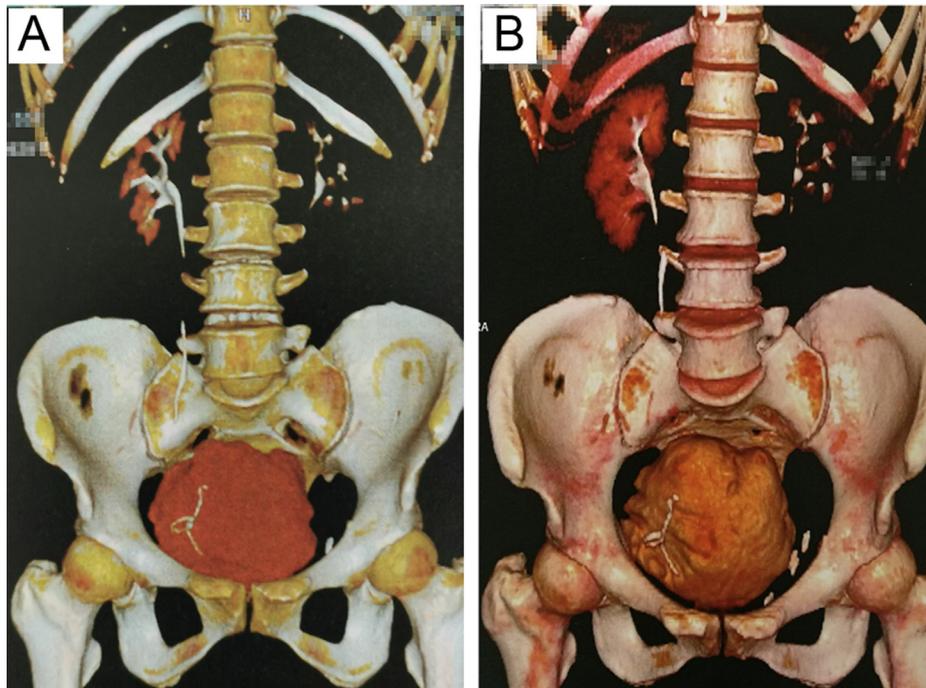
Computed tomographic urography imaging of an orthotopic neobladder suspended with round ligaments at (A) 6 mo and (B) 12 mo.
